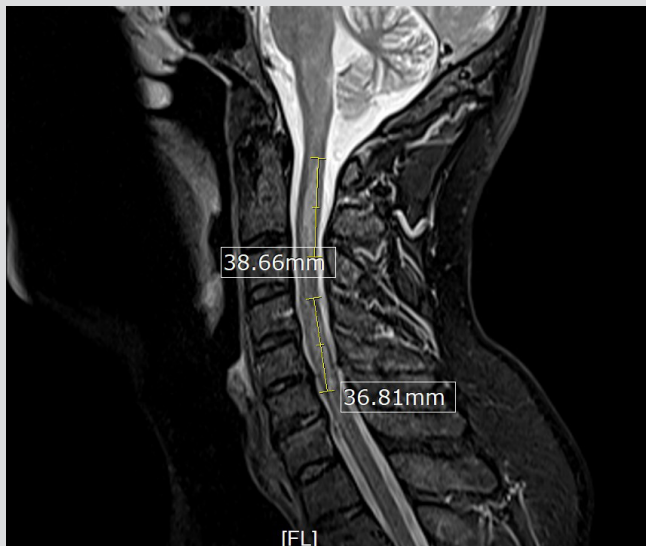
MRI of the cervical spine showing long segments of increased cord signal with C2–C5 involvement
